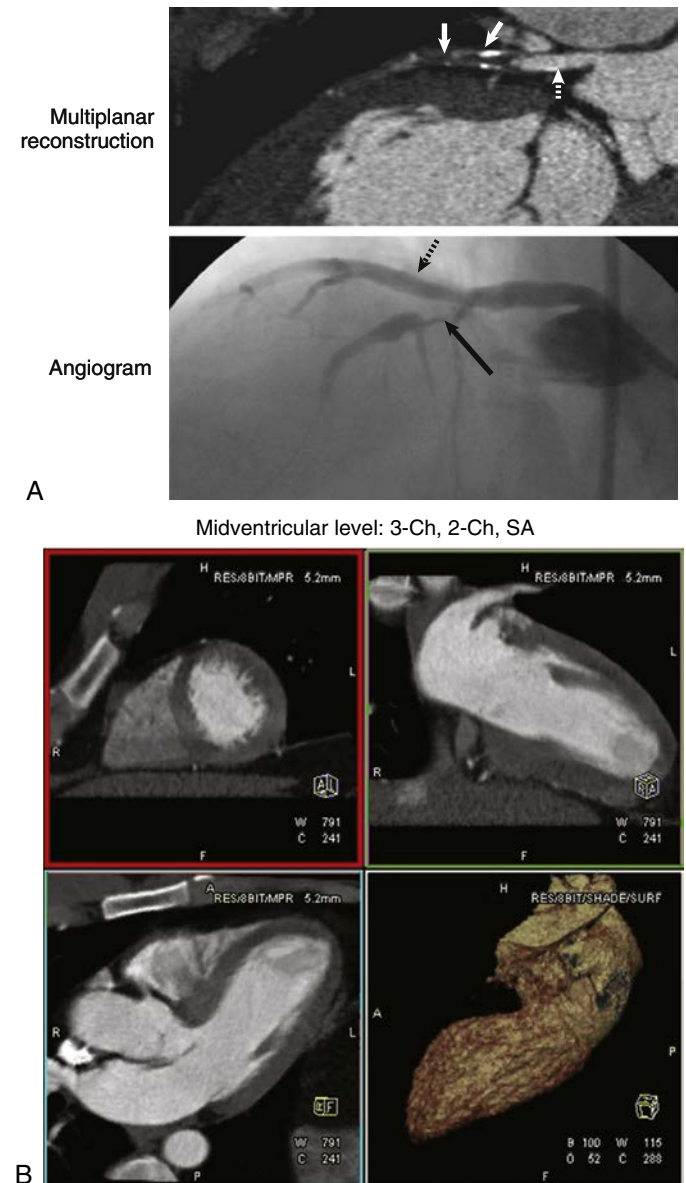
(A) Upper level, Multiplanar reconstructed CT image of the left anterior descending coronary artery, demonstrating a contrast-filled lumen at the beginning (dashed white arrow) of the procedure. After approximately 2 cm, the lumen over a long segment (white solid arrows) is filled with low attenuation material, representing either noncalcified plaque or acute thrombus. Because of the presentation of the patient, acute thrombotic subtotal occlusion is more likely. Partial reconstitution of the lumen occurs. Some wall calcifications are also visible. Lower level, invasive coronary angiogram of the left ascending coronary artery. Subtotal occlusion of the proximal left anterior descending artery as seen in CT (solid black arrow). Patent large first diagonal branch (dashed black arrow). (B) Midventricular level, Three- and two-chamber, and short-axis cine loops as well as a left ventriculogram. Hypokinesia by absence of wall thickening in systole of the septal and anterior wall is demonstrated. Left ventriculography shows that the contrast blood close to the anterior wall is not moving during the cardiac cycle.
